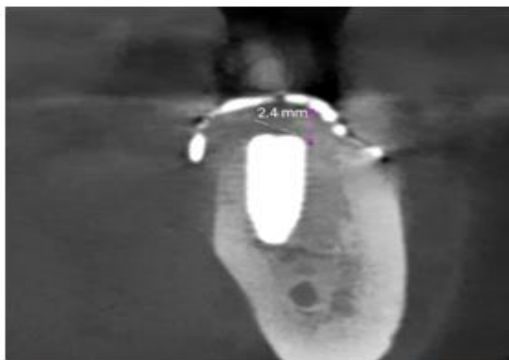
post-operative CBCT showing increase in width
